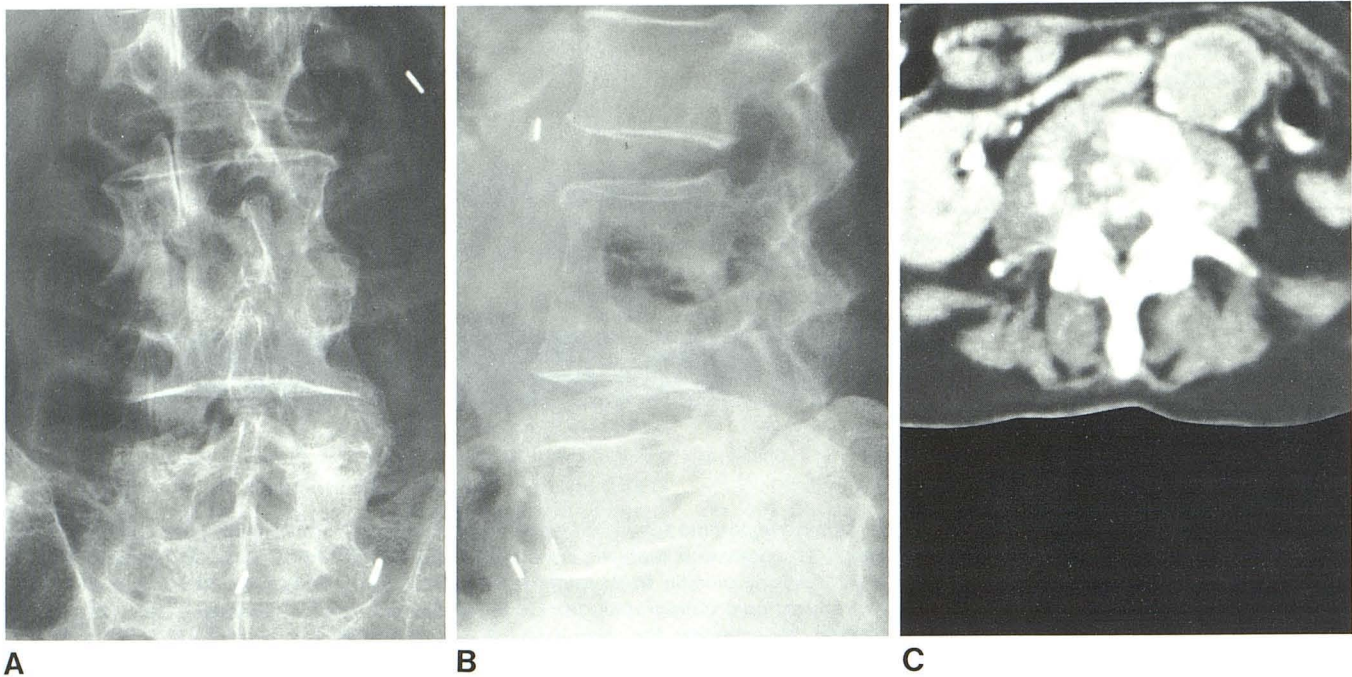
Case 1. Staphylococcal osteomyelitis L3–L4. S/P aortic graft surgery. Anteroposterior (AP) (A) and lateral (B) views of lumbar spine. Loss of L3–L4 disk space and destruction of adjacent vertebral end-plates. Clips in abdomen from previous graft surgery. C, CT of inferior aspect of L3 after
